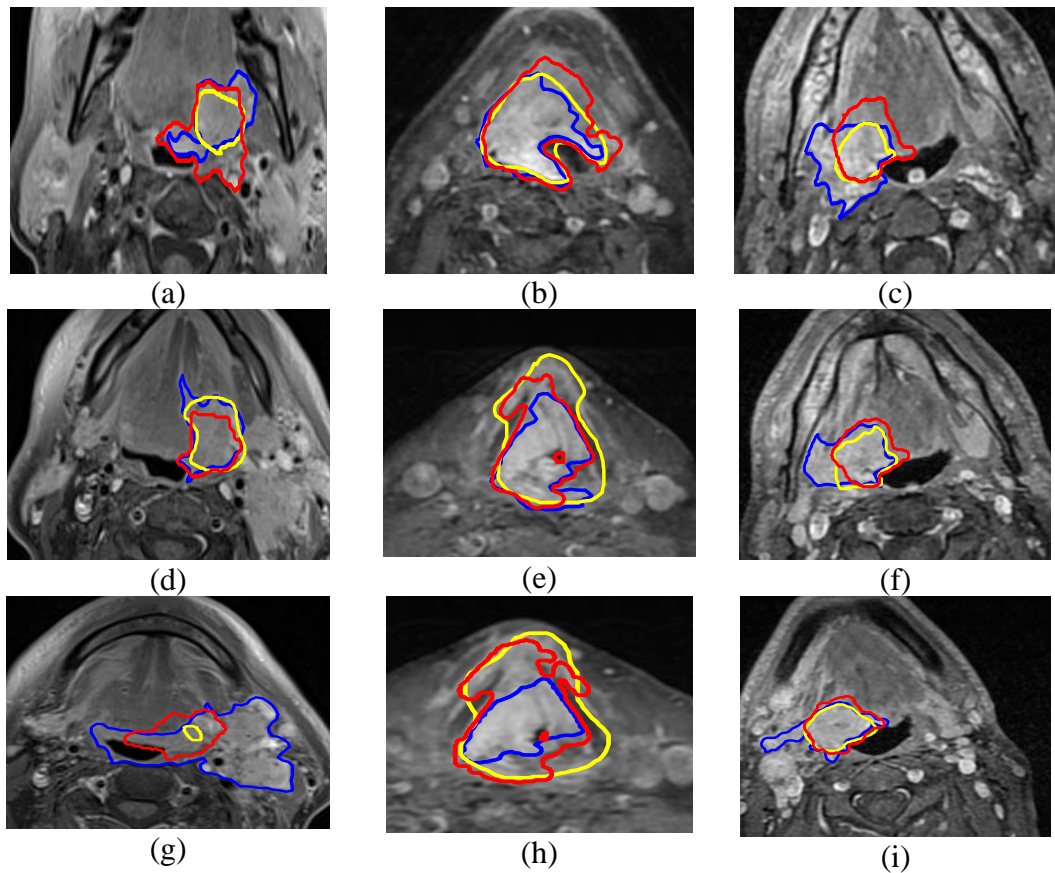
Examples of T1 axial MRI slices with HNC drawn by manual (yellow), methods in [193] (blue), and proposed automatic algorithm (red). (a-c) are from first patient. (d-f) are from second patient
